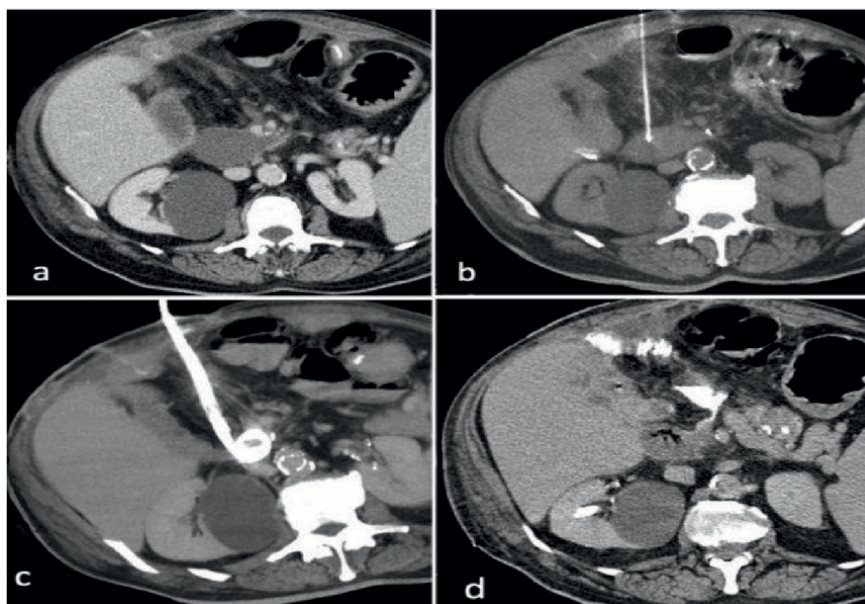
Drainage of a retroperitoneal fluid after pancreatic surgery (a). Percutaneous puncture with a Chiba needle (b), a 12Fr pigtail catheter placed (c) MIP reconstruction using the Seldinger technique. Repeat CT after 2 weeks with complete resolution (d) [26].
